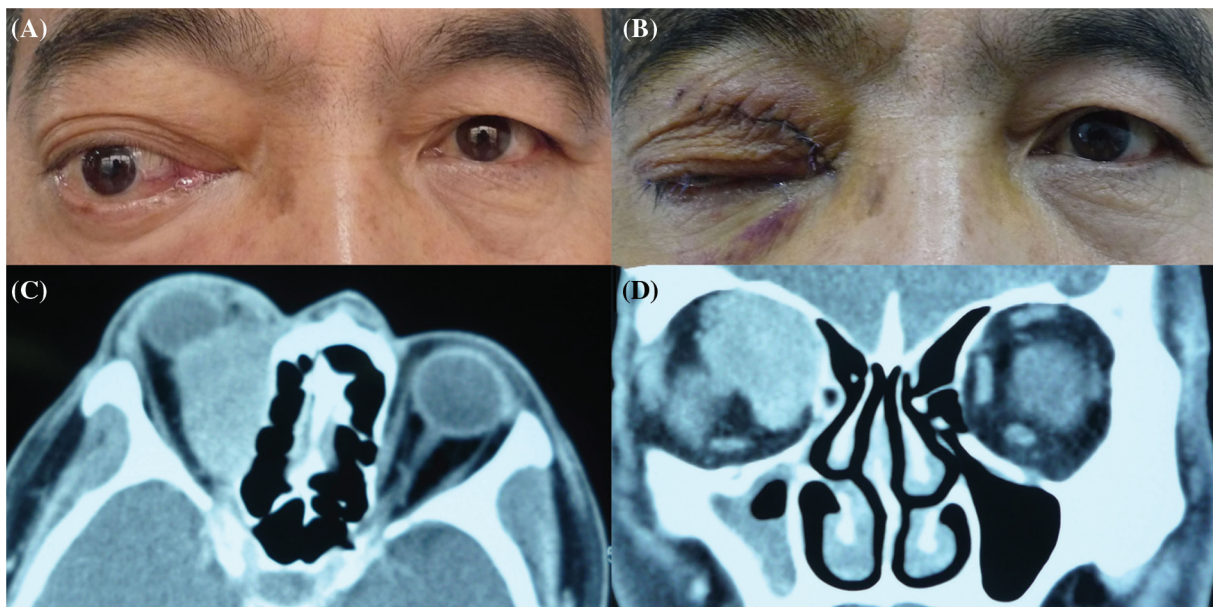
(A) The preoperative image showed proptosis of the right eye. (B) The postoperative image showed that the right eyelid closed entirely. (C) and (D) Orbital CT scan demonstrated a large, homogeneous mass surrounding the optic nerve and the medial rectus muscle in the right orbit
